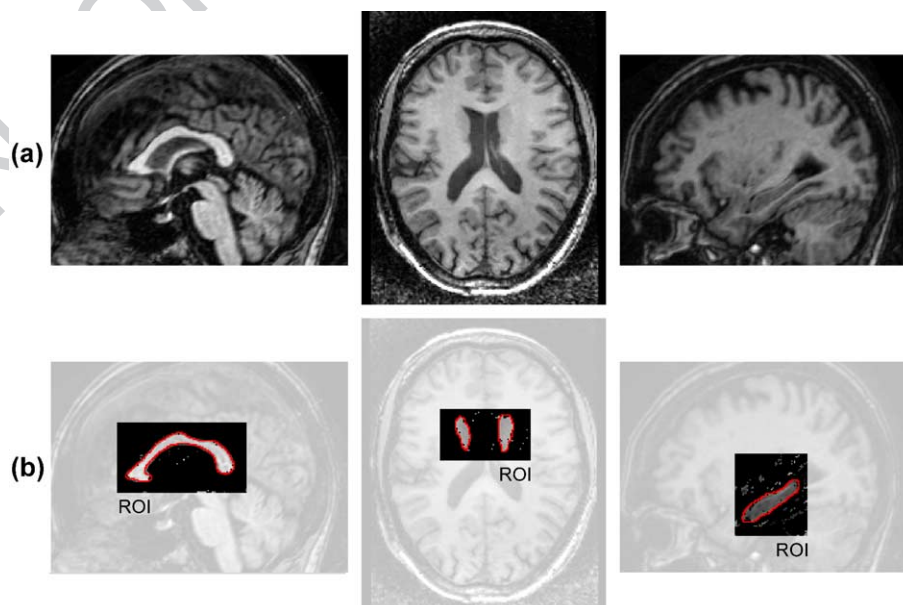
Neutral classification of corpus callosum, caudate nucleus and hippocampus: (a) input T1-weighted 1 mm<sup>3</sup> MRI; (b) neutral extracted structures with true outlines superimposed.
